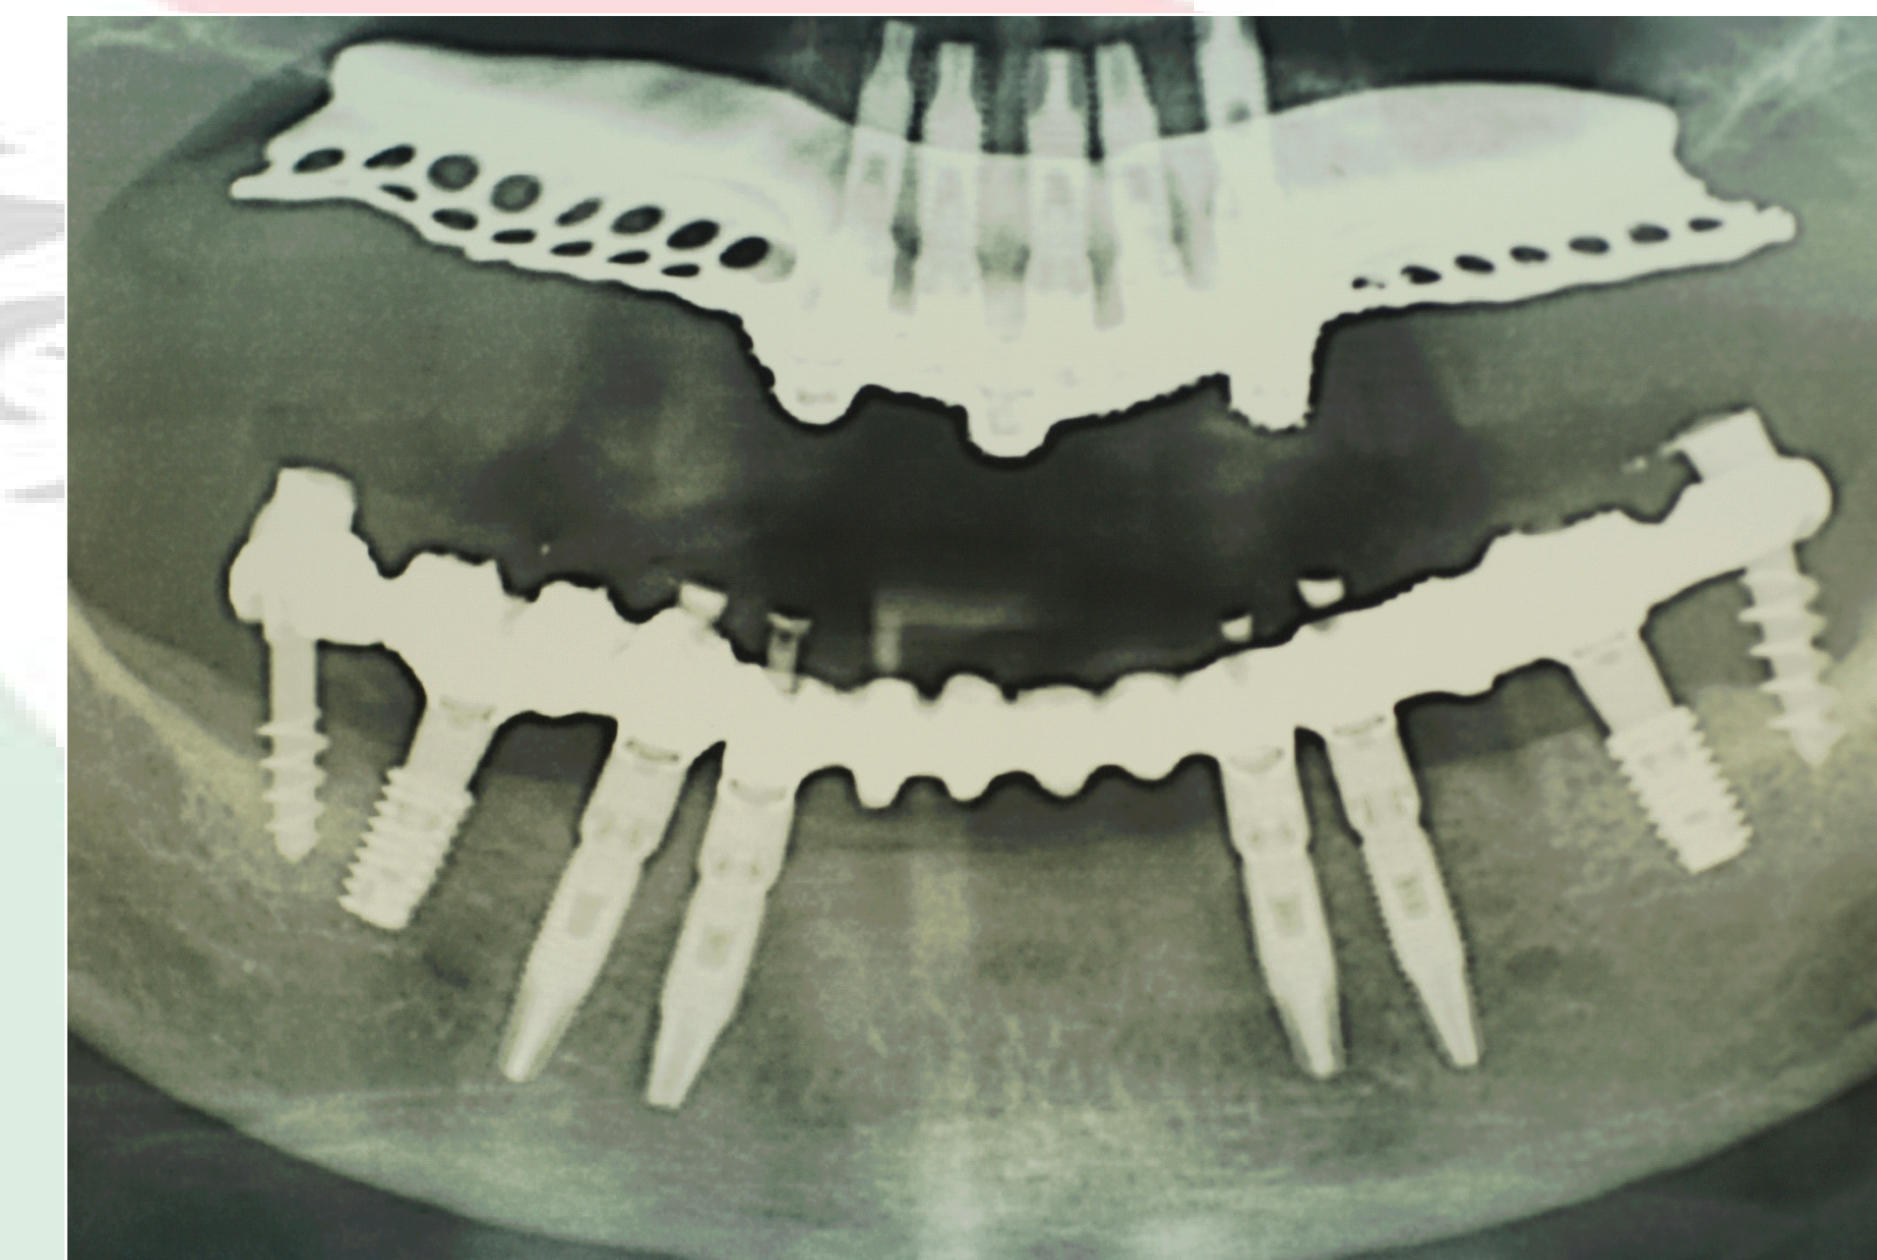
Radiographic control of the patient after treatment. The distal implants are maintained because of their clinical stability
